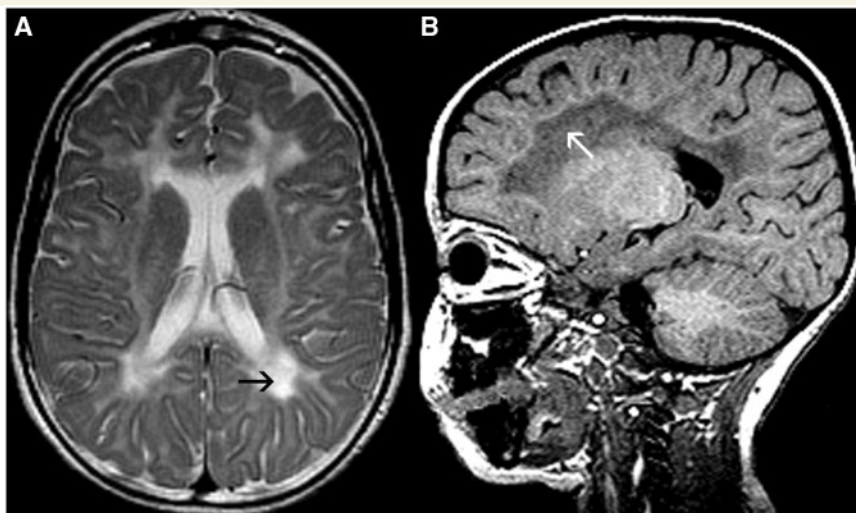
MRI of a 3-year-old male with HCC. The axial T₂-weighted image shows prominent T₂ hyperintensity (black arrow, A) and the sagittal T₁-weighted image displays T₁ hypointensity (white arrow, B) of the periventricular and deep white matter.
